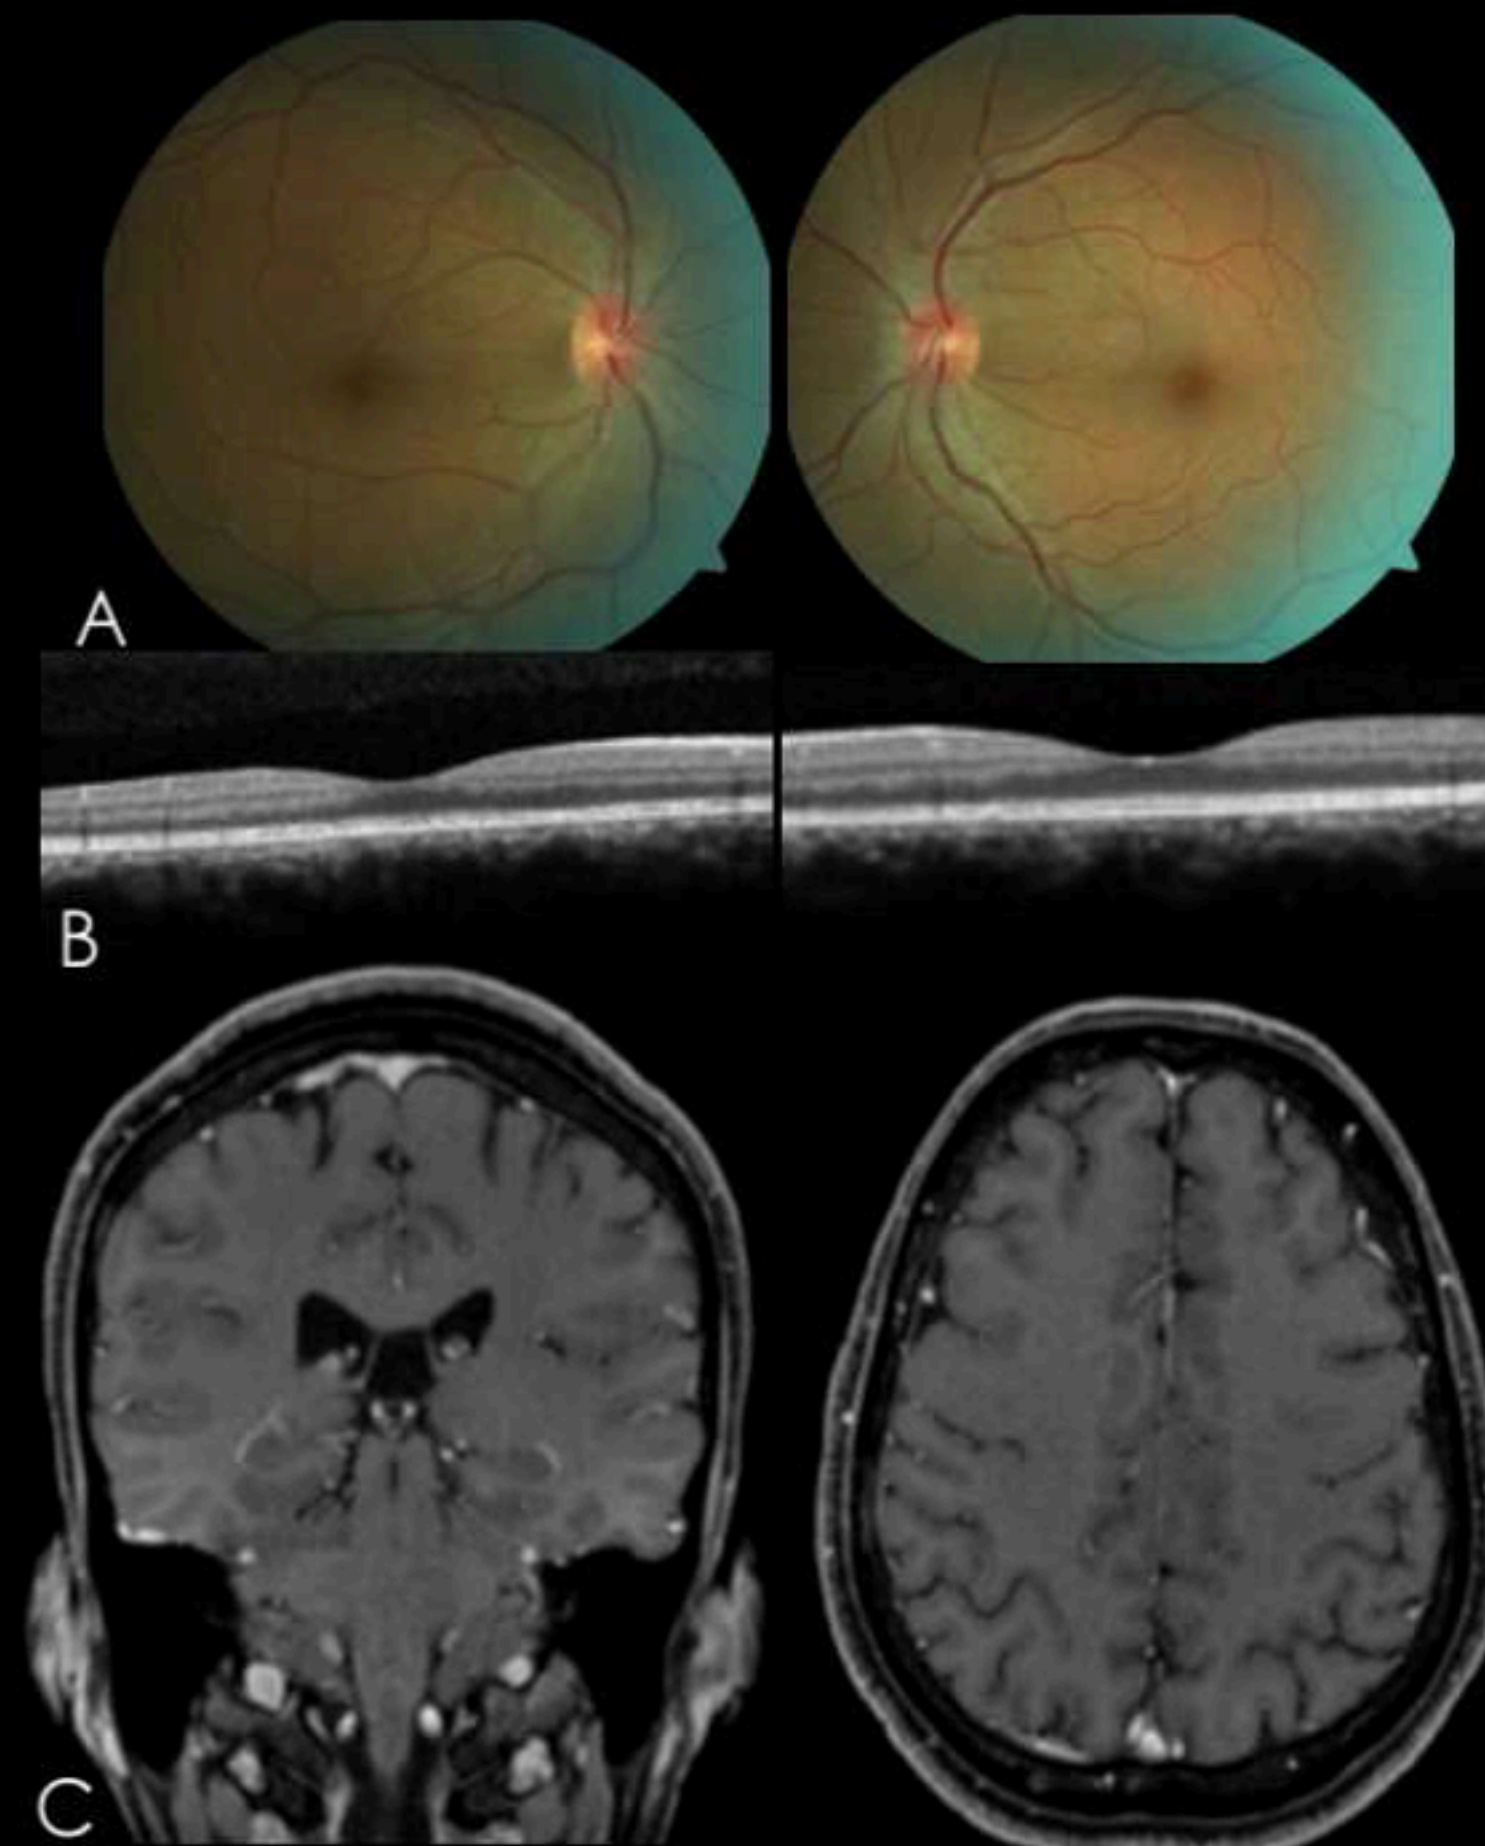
A – Posterior pole of the right and left eye after treatment. B – OCT of the right and left eye after treatment. C – MRI showing resolution of the cranial and dural processes.
